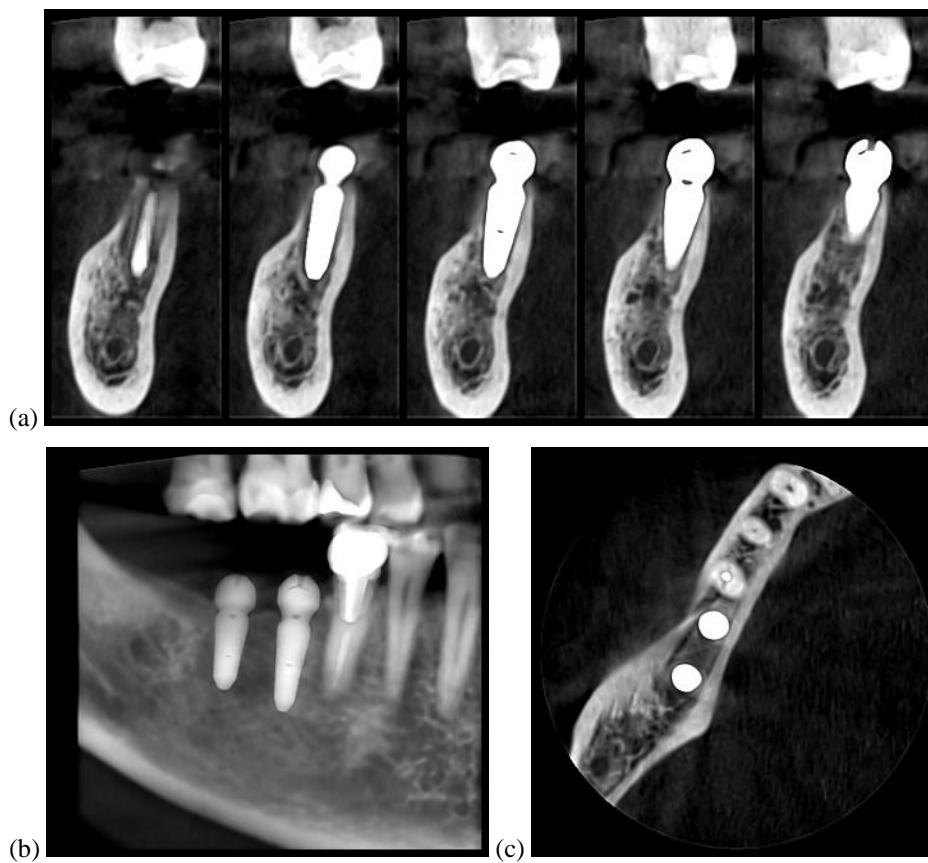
3D CBCT after implant insertion on different views: (a) implant, (b) panoramic, (c) axial.
